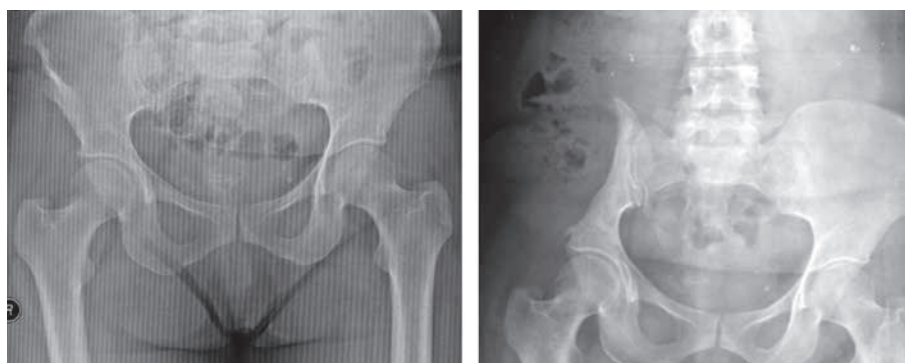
46-year-old female with hydatid disease of the right ilium. Left : plain radiographs, preoperatively : lytic area with sclerosis. Right : after ilium type I resection, without reconstruction.
